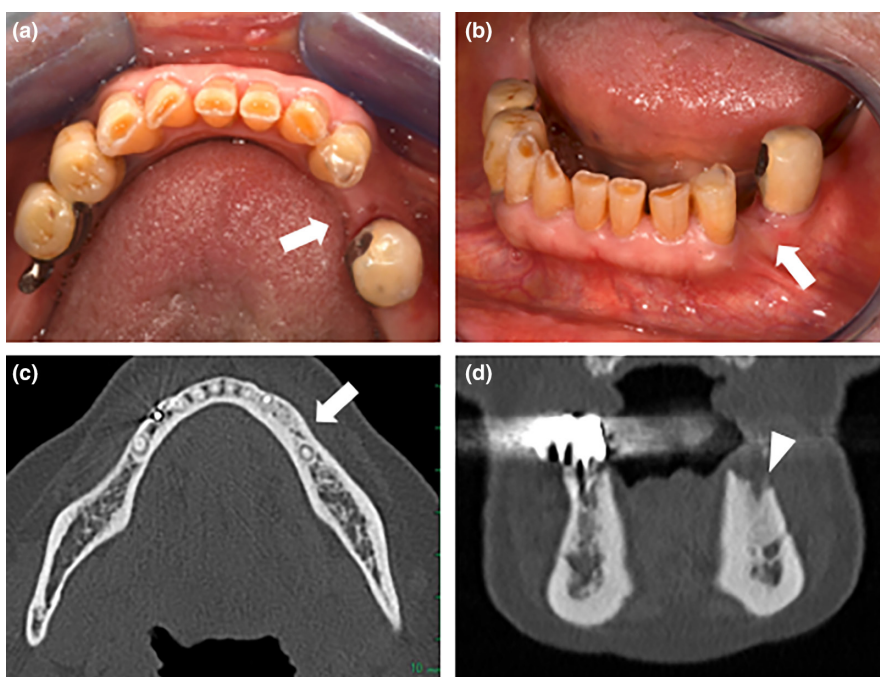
Stage 1, Focal MRONJ. Panel a: clinical view showing non-exposed MRONJ in the left posterior mandible (white arrow). Panel b: anterior view of the same lesion displays probing bone mucosal fistula (white arrow). Panel c and d: axial and coronal CT reconstructions show bone marrow sclerosis that is limited to the alveolar jawbone (white arrow and white arrow-head respectively).
